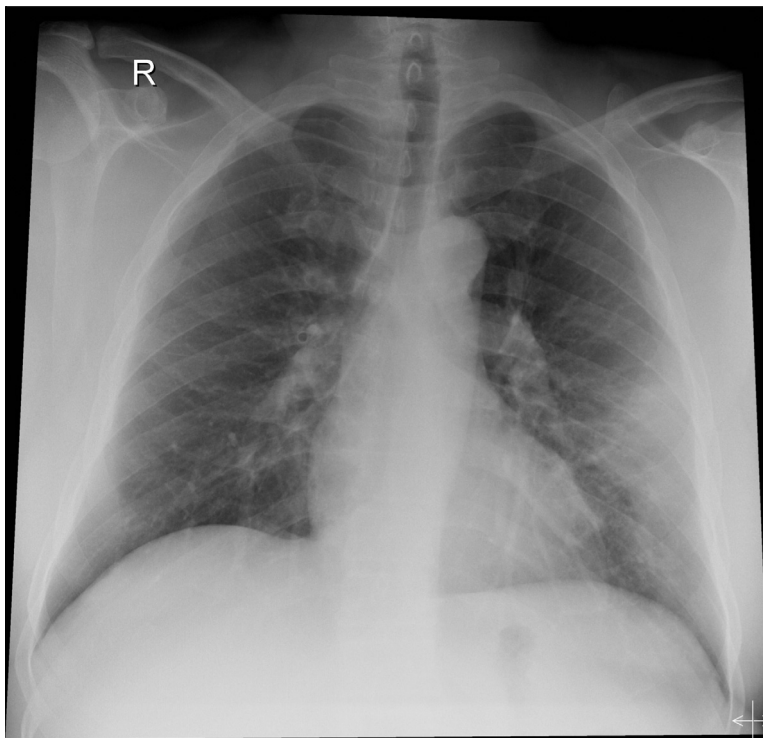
A case of MERS-CoV; Chest X-ray; frontal projection at day of presentation showing left lower zonal pleural based peripheral opacity.
